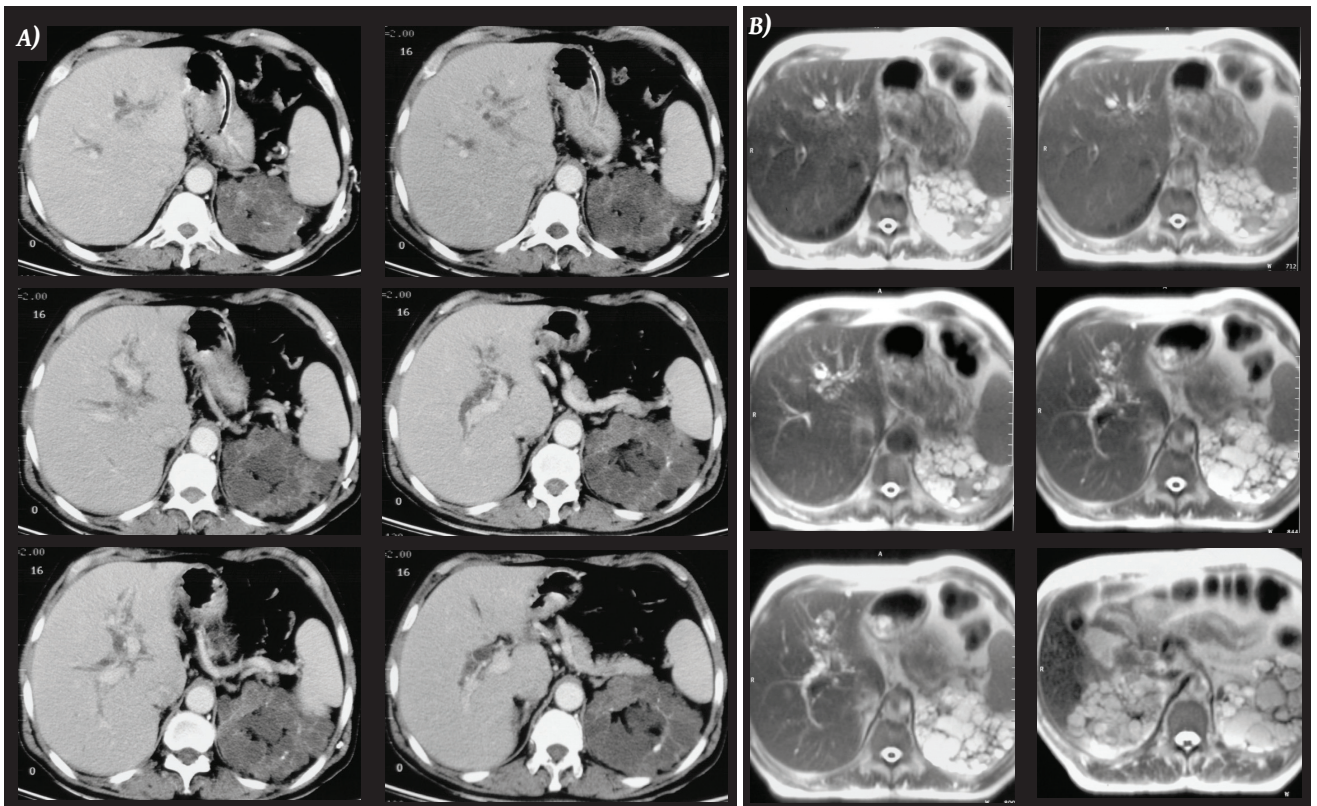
Intrahepatic peribiliary cysts in a patient with ADPKD. a) axial CT images and b) MR T2WI axial images reveal the peribiliary cysts and the polycystic disease of the kidneys.
